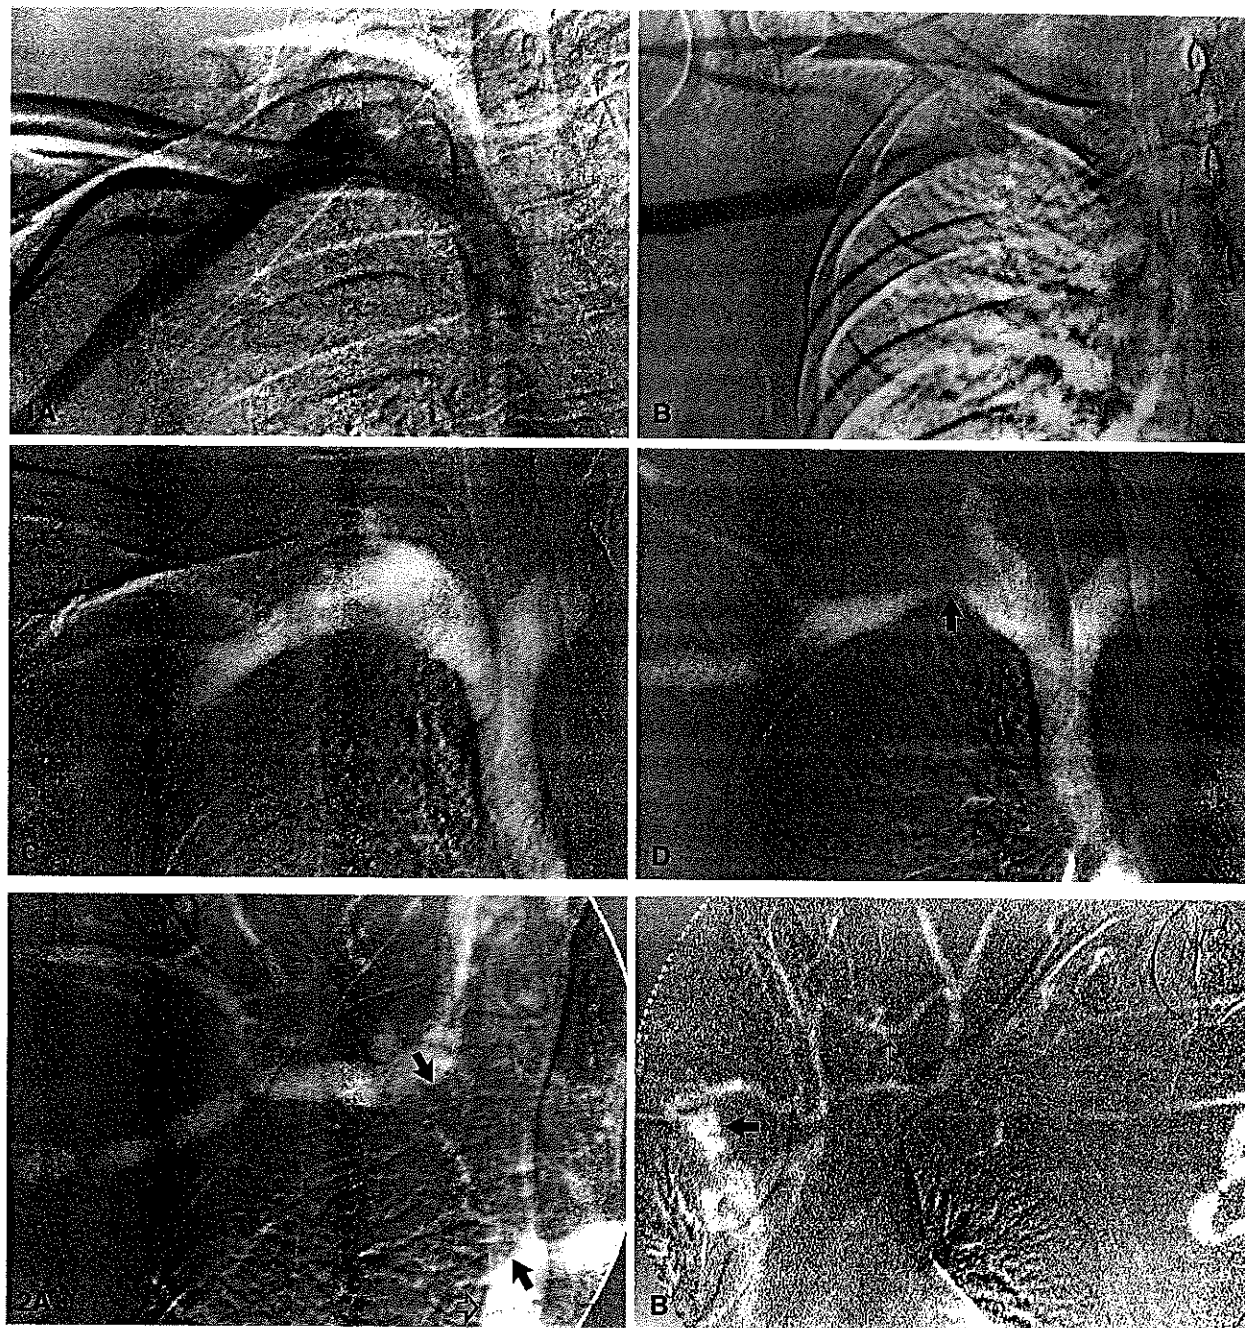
A The right subclavian and innominate veins were poorly visualized with IC in this patient with thoracic outlet syndrome. B Abduction of the arm lead to even poorer opacification of these veins with IC. This radiograph was obtained 13.5 sec after contrast injection. Doppler ultrasound revealed slow axillary vein flow, especially with abduction of the arm. Subtraction artifact resulting from patient motion during the long image-acquisition sequence contributed to poor image quality. Slow flow probably diluted the IC, also contributing to the poor quality. C CO₂ venography demonstrated normal subclavian and innominate veins in the same patient with the arm adducted. The nonvisualized portions of the axillary and cephalic veins were normal on other images in this venogram. D CO₂ venography with the arm abducted revealed compression of the subclavian
